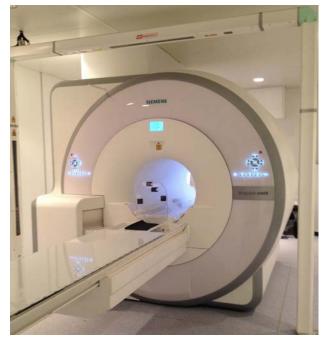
PET/MRI with the flat tabletop positioned on top of the conventional radiofrequency spine array coil and the systems patients table.
